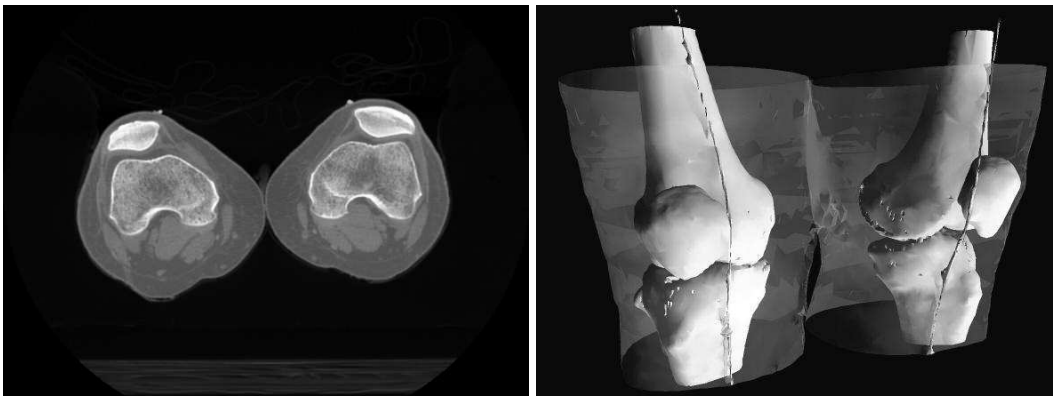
Conventional CT slice for diagnosis (left) and machine generated VR view (right).
